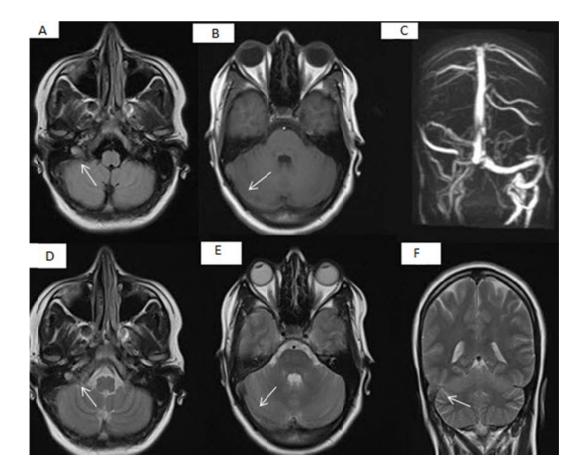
Study of MRI and PC-MRV Routine Sequences in the First Patient: The right internal jugular vein thrombosis in T1W image (A) and T2W (D) has high signal intensity. However, the right transverse and sigmoid sinus thrombosis is shown with the same strength as the parenchyma. Lateral sinuses and anterior superior sagittal sinuses are rarely seen in the axial view. The right transverse sinus thrombosis in T2 coronal cutting (F) has high signal intensity. Transverse and right sigmoid sinus thrombosis and internal jugular vein are observed in MIP PC-MRV image (C) with the absence of signals from the arterial body flow.
